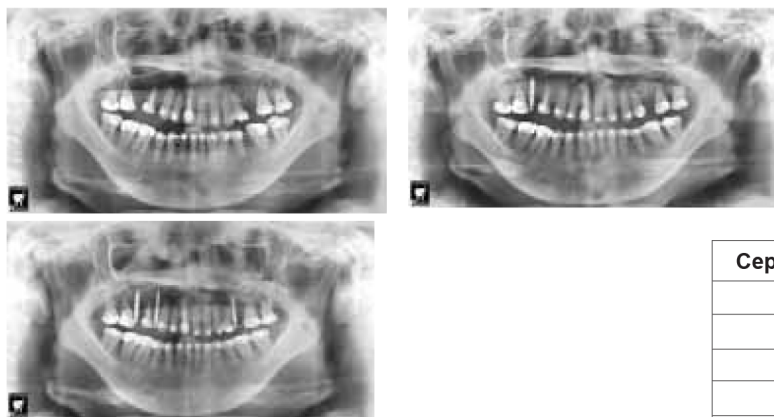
Panoramic radiographs A) Post-surgical , B) 11th month, one implant was inserted to replace missing 16, radiopacity at the area of previous impaction 25 indicated deposition activity of bone; C) 15th month, 3 narrow diameter implants were inserted due to insufficient bone width.
